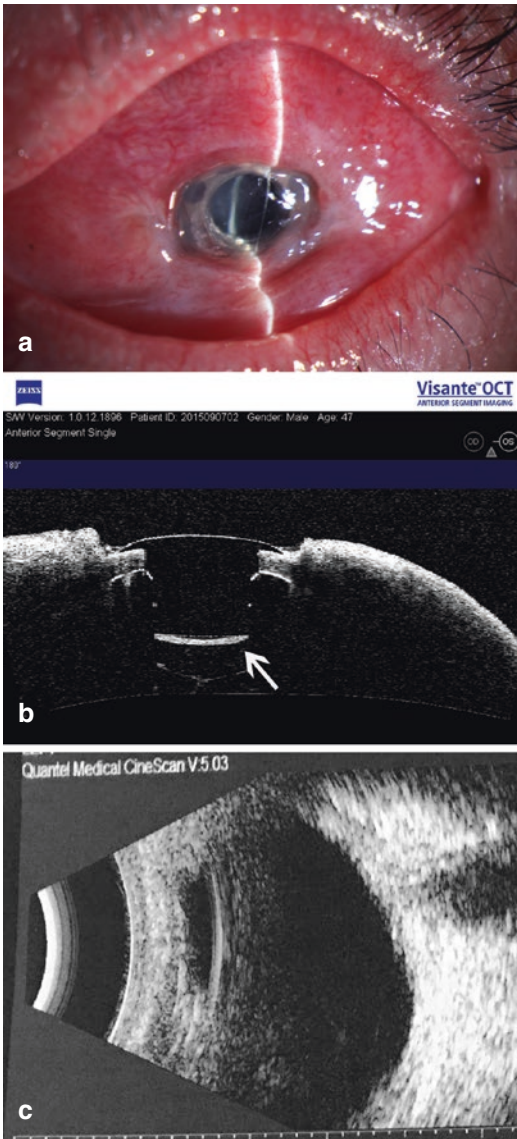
Retroprosthetic membrane (RPM) after KPro I surgery. (a) Slit lamp demonstrated RPM 5 months after KPro I implantation in a patient injured by alkali chemical burns 18 years ago. (b) Anterior segment optical coherence tomography showing a thick RPM (arrow). (c) B-scan ultrasonography showing the presence of sterile vitritis after ruling out infection
